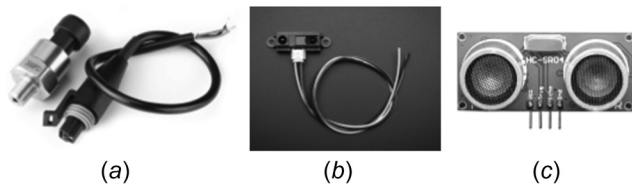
(a) Pressure transducer sensor, (b) infrared distance sensor, and (c) ultrasonic distance sensor
